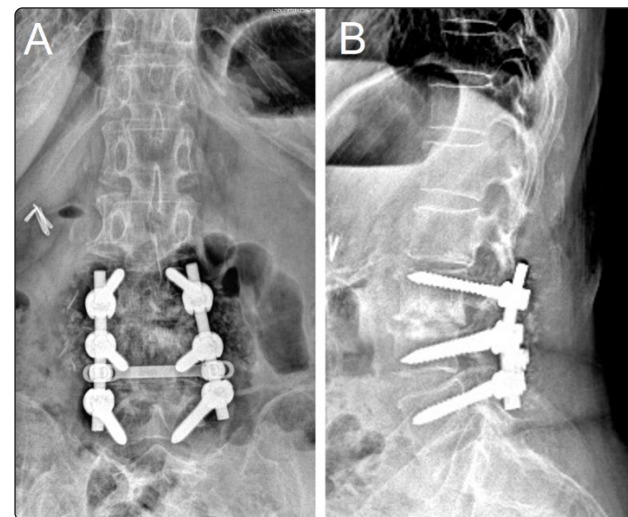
X-ray of the lumbosacral spine: (A) anteroposterior view and (B) lateral view, showing irregularity of L3-L4 disc space and posterior pedicle screws fixation of L3-L5 with decompression and posterolateral fusion.
